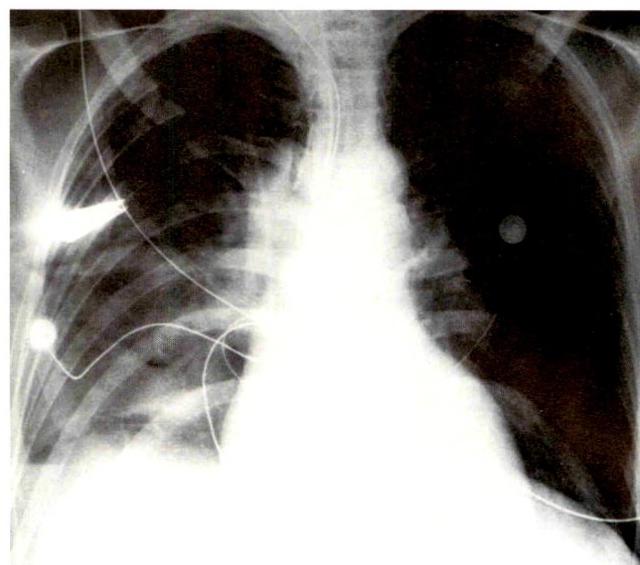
Chest x-ray demonstrating severe right unilateral pneumonic process. In addition, blunting of the right costophrenic angle was noted.
